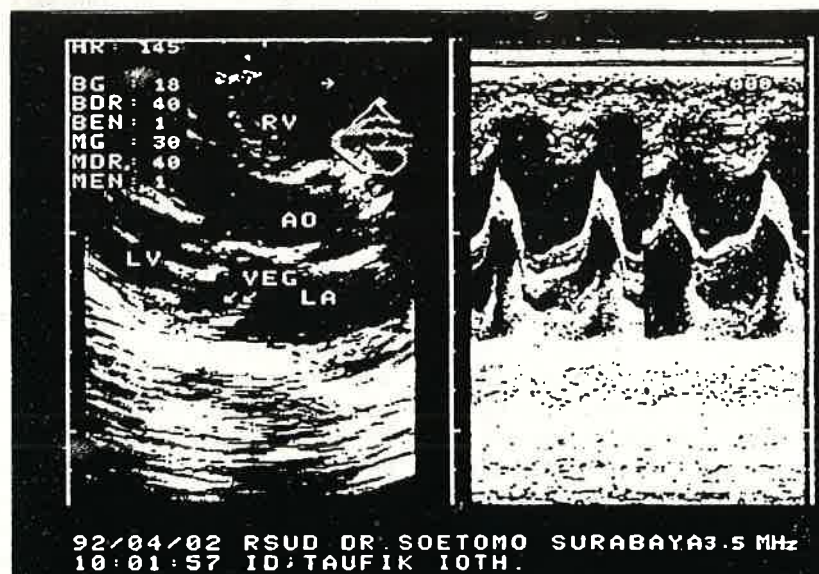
+ 1b. The echocardiographic examination showed that the mitral valve was slightly thickened and there was vegetation on the atrial surface of the mitral valve.
